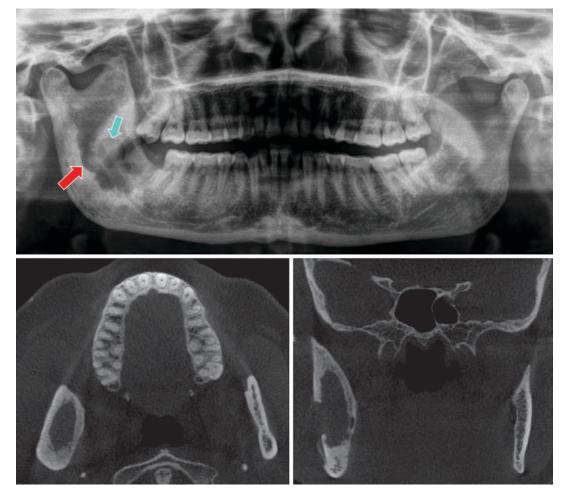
Primary intraosseous carcinoma in odontogenic keratocyst. (a) OPG reveals a lesion with ill-defined scalloped borders and radiolucent internal structure (red arrow) at mandibular right ascending ramus. Another round-shaped area with lower density is seen inside the lesion suggesting cortical destruction (turquoise arrow). (b) Coronal CBCT slice of Fig. 18.2 reveals buccal and lingual cortical plate expansion and buccal cortical plate
